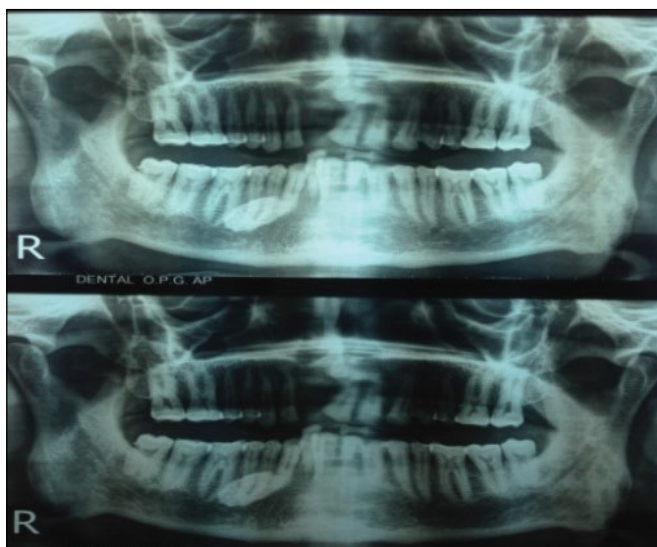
Orthopantomograph showing radiopaque mass in right body of mandible).
